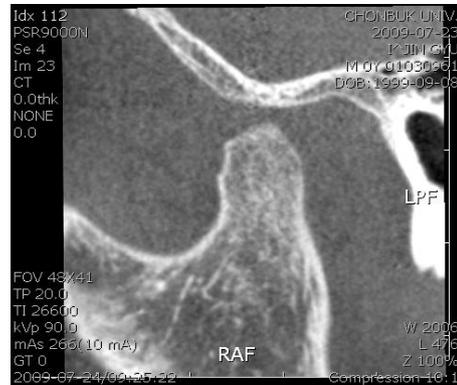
Sagittal view of left mandibular condyle at 4 month after discharge by cone beam CT.
